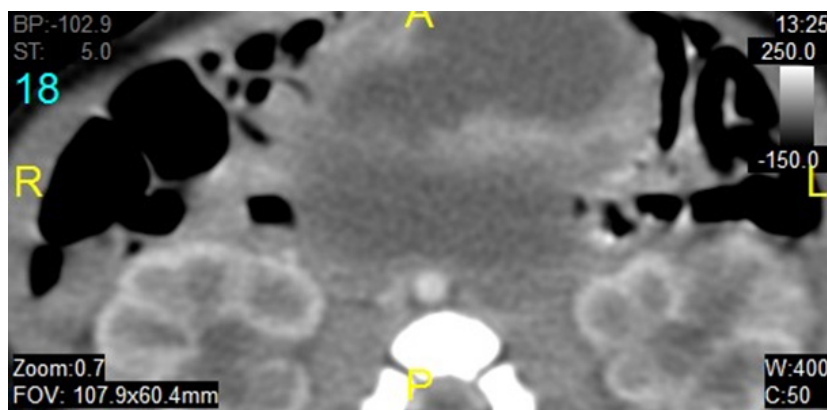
and 6B: CT-scan and intravenous urography showing bilateral hydroureters and hydronephrosis in a newborn with McKusick-Kaufman Syndrome. The hydroureteronephrosis was secondary to pressure effect from the markedly distended vagina and uterus (Hydrometrocolpos).
